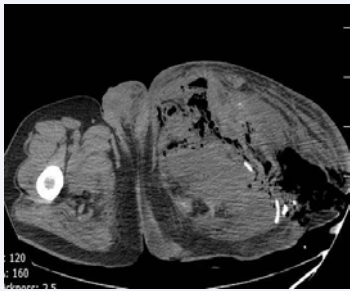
CT-scan of pelvis show distraction of hip joint and proximal portion of femure with sever swelling and air in the muscles.
